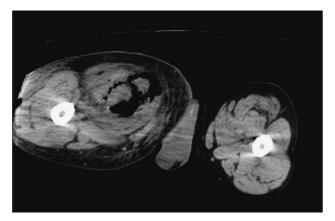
Computed tomography scan demonstrated softtissue inflammation and edema with multiple gas bubble formations and generalized from the obturator muscle to the femoral muscle.
